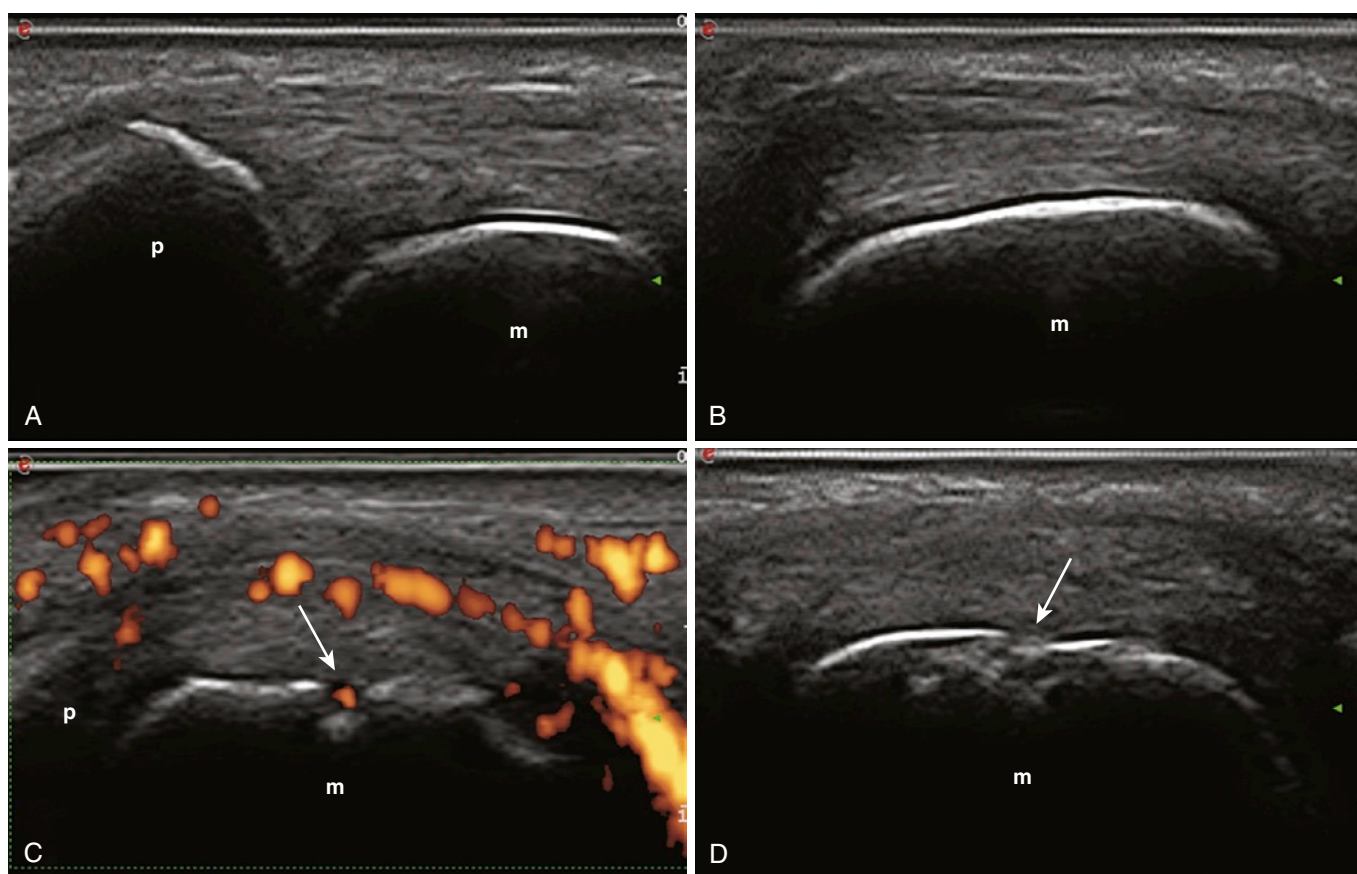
RHEUMATOID ARTHRITIS OF THE HAND. The radial aspect of the second metacarpophalangeal joint is compared in the right (A and B) and left (C and D) hands. The longitudinal (A) and transverse (B) scans do not show signs of cartilage involvement. Corresponding views acquired on the contralateral side show subchondral bone erosion (*arrows*). On the longitudinal view (C), power Doppler technique allows the detection of signal at the level of the subchondral bone erosion. m, metacarpal head; p, proximal phalanx.
